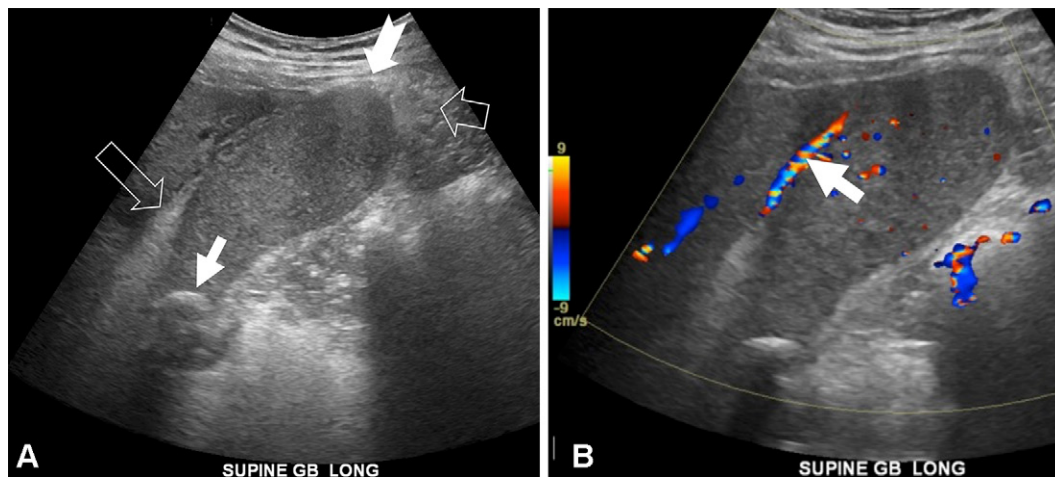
Acute cholecystitis in a 63-year-old man. (A) Gray-scale longitudinal US image of the gallbladder shows a thin gallbladder wall without pericholecystic fluid. However, other findings suggestive of acute cholecystitis are seen, including marked gallbladder luminal dilatation to 11.5×4.2 cm (measurements not shown), a subtle tensile fundus sign (thick solid arrow), echogenic pericholecystic fat adjacent to the gallbladder fundus (short open arrow) and in the triangle of Calot (long open arrow), intraluminal sludge, and a lodged gallstone (thin solid arrow) at the gallbladder neck. (B) Color Doppler US image of the gallbladder shows moderate hyperemia of the cystic artery (arrow).
